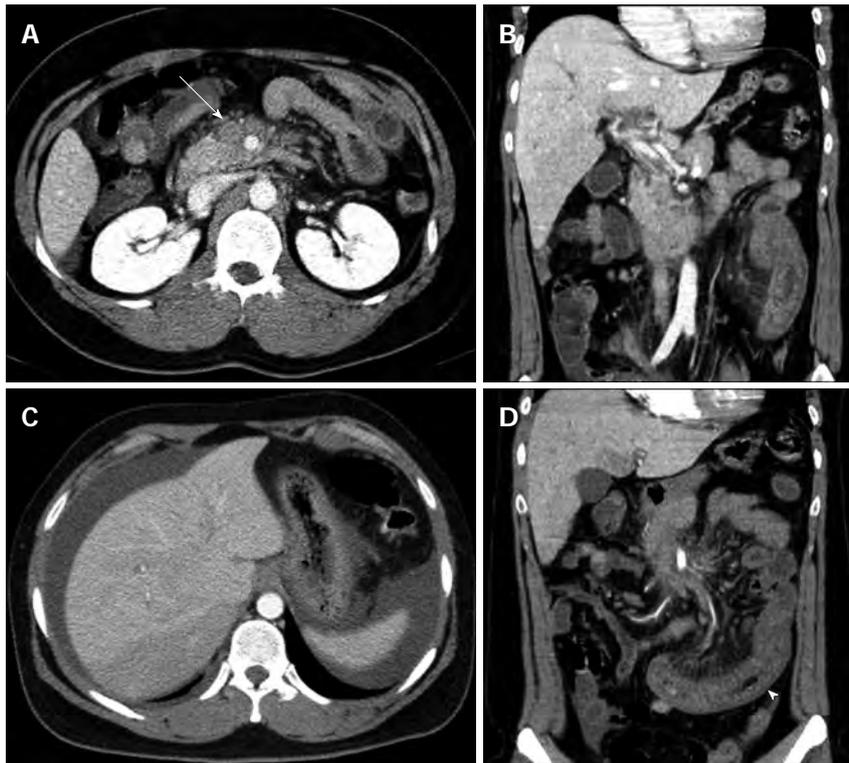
Abdominal computed tomography demonstrates an acute mesenteric venous thrombosis at the time of initial presentation. A: A thrombus (arrow) and perivenous infiltration at the proximal superior mesenteric vein; B: extension into the portal vein; C: An abnormal fluid collection around the liver and spleen; D: The affected small bowel (arrow head) with long-segment wall thickening and decreased enhancement.
